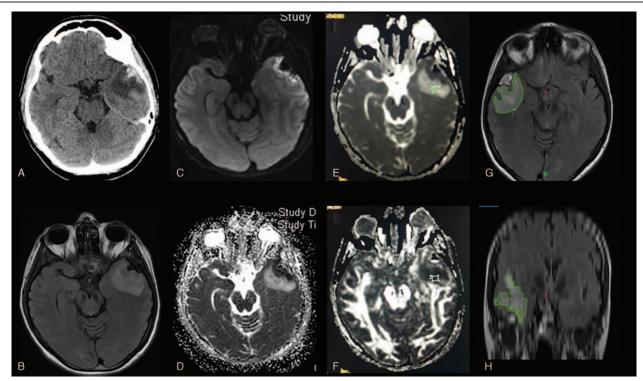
Example of a traumatic brain injury patient with a brain contusion and pericontusional edema. A. Computed tomography showing a left temporal contusion with pericontusional edema. B. Fluid-attenuated inversion recovery sequence showing the pericontusional edema. C. Axial diffusion map that shows a reduction in signal in the left temporal pericontusional area. D. Apparent diffusion coefficient map that shows an increased signal in the left temporal pericontusional area. D. Apparent diffusion coefficient map that shows an increased signal in the left temporal pericontusional area. E. Apparent diffusion coefficient map obtained with the Advantage Window VolumeShare of General Electric Medical System, Software version 4; Functool 9.4 program (General Electric Medical Systems, Chicago, IL). The regions of interest can be visualized and it is placed in the left temporal pericontusional vasogenic edema. F. Fractional anisotropy map obtained with the Functool 9.4 program. The regions of interest can be visualized and is placed in the left temporal pericontusional vasogenic contusional vasogenic edema. G. Example of volume measurement using the Medtronic Navigation (StealthViz 1.3.0.34). Volume measured in the left temporal contusion seen in the axial cube- fluid-attenuated inversion recovery sequence and coronal cube-flair sequence (Fig. 1H).
